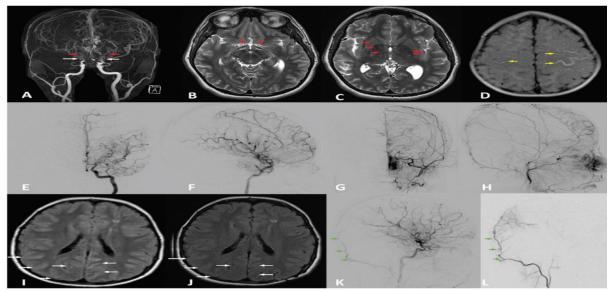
Radiographic imaging modalities for diagnosis and follow-up of moyamoya It includes magnetic resonance angiogram (MRA) coronal view (A) demonstrating bilateral stenosis and occlusion (white arrows) of the internal carotid artery (ICA) terminus, M1 segment of middle cerebral artery (MCA), and A1 segment of anterior cerebral artery (ACA). Notice extensive proliferative changes of the lenticulostriate arteries bilaterally (red arrows). Axial brain MRI T2WI, at level of basal cisterns (B) and basal ganglia (C) demonstrate void signals (red arrows) of moyamoya collaterals. Axial brain MRI FLAIR sequence (D), showing ivy sign bilaterally (yellow arrows). Anteroposterior (E) and lateral (F) digital subtraction angiogram (DSA) of the left ICA show stenosis of the terminal ICA and thread-like appearance of the M1 and A1 segments, with reconstitution of MCA and ACA candelabra by lenticulostriate collaterals; most consistent with Suzuki stage III. Anteroposterior (G) and lateral (H) DSA of the left external carotid artery (ECA) shows intrinsic ECA to ICA transdural collaterals from middle meningeal and superficial temporal artery. Atypical moyamoya with posterior cerebral disease (I-L): preoperative (I) and postoperative (J) FLAIR sequence showing preoperative ivy sign and its disappearance following pial synangiosis (white arrows). Preoperative lateral DSA of left ECA (K) and postoperative lateral DSA of left occipital artery (L) following pial synagniosis using the occipital artery as a donor, demonstrating ingrowth of collaterals from the occipital artery. Notice the increased size of the donor artery (green arrows) compared to the preoperative DSA
